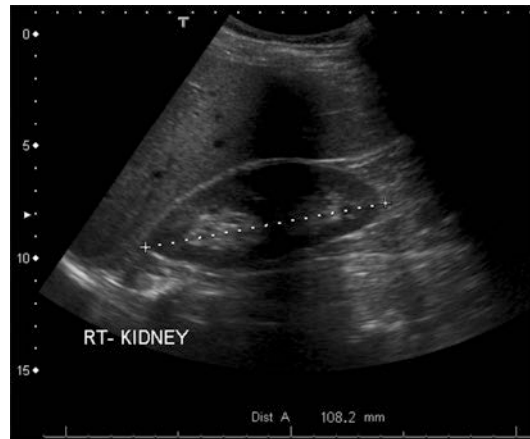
Ultrasound imaging of the kidneys. A normal right kidney in the sagittal plane: the top of the ultrasound image is anterior; the bottom is posterior. Right on the image is towards the feet (caudal) and left is towards the head (cranial). The right liver lobe overlies the kidney; the right kidney cortex and medulla are well-differentiated; the interpolar length has been measured as 108.2 mm. Note areas of increased shadowing are produced by the ribs
